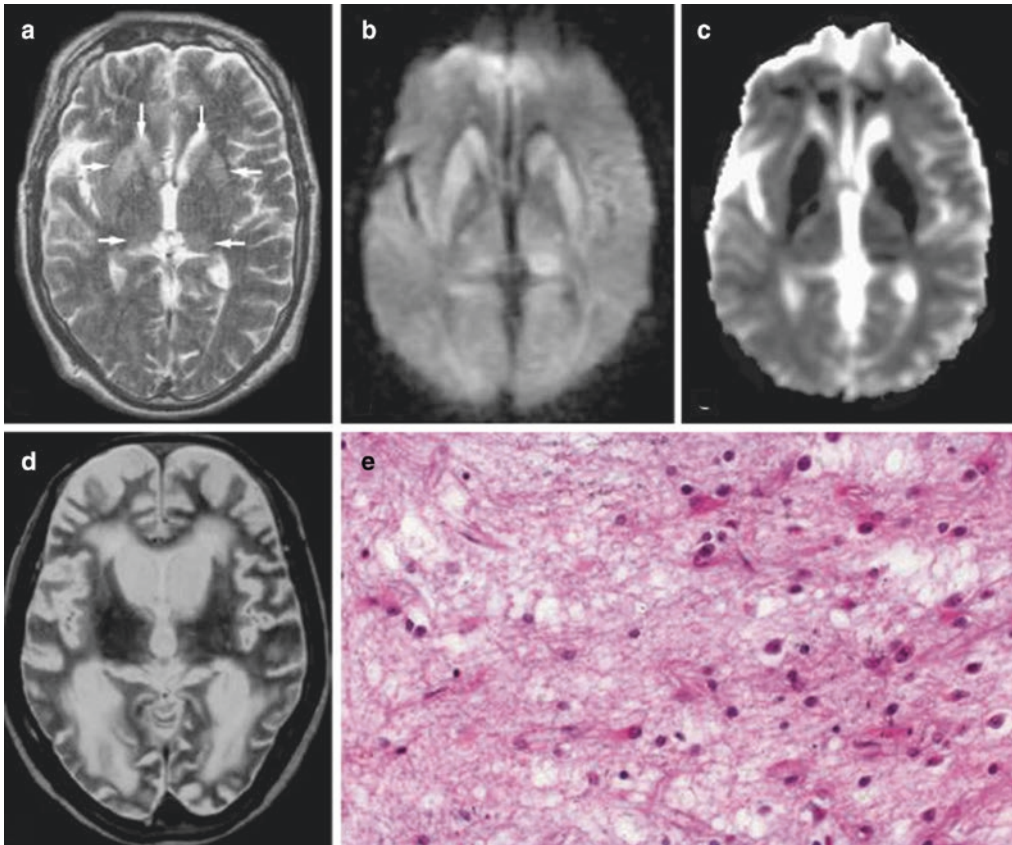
Creutzfeldt-Jakob disease in a 51-year-old man with progressive dementia. (a) T2-weighted image demonstrates mild hyperintensity bilaterally in the caudate nuclei, putamina, and pulvinar of the thalami (*arrows*). (b) DW image clearly demonstrates these lesions as hyperintense. (c) ADC is decreased. (d) A
